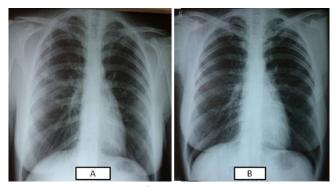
Daughter of patient 'chest X-ray was seen pneumonic infiltration at in right middle zone during diagnosis of lung tuber-culosis (TB) (A) and (B) following treatment for lunf TB disease
